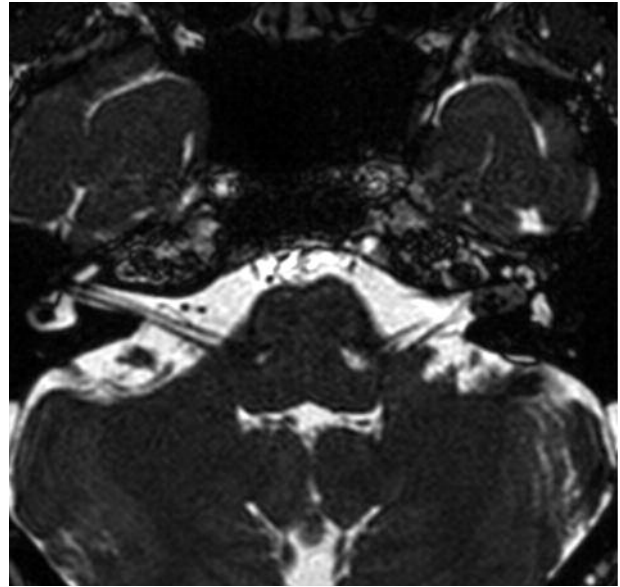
Axial T2 weighted MRI shows a 6-10 mm mass isointense in the left ICA lesion with several tiny focal hypointensities.
